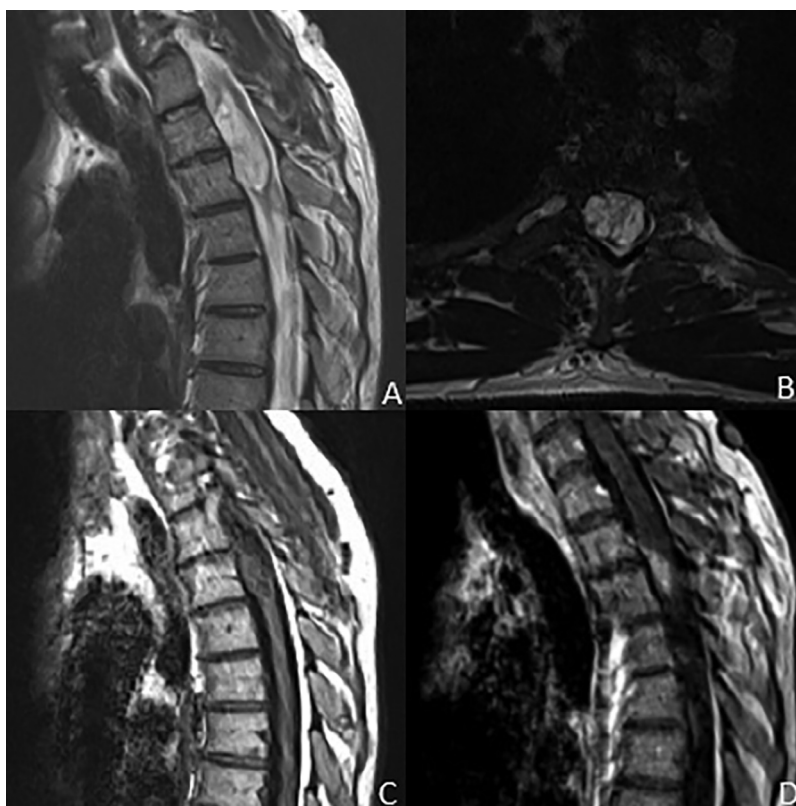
Sagittal (A) and axial (B) T2-weighted magnetic resonance imaging (MRI) of the thoracic spine on the patient’s initial presentation demonstrates an expansile intramedullary mass from T1 to T3-4. Sagittal T1-weighted pre- and postcontrast MRI (C and D) demonstrate enhancement of the mass.
